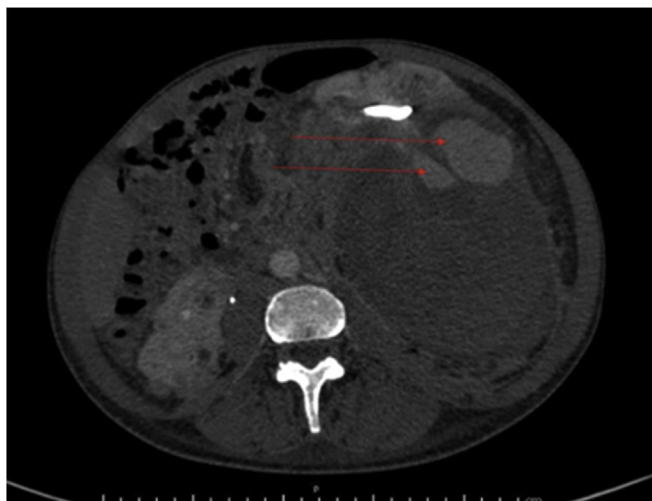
Abdominal computed tomography scan showing areas of contrast extravasation (red arrows).
